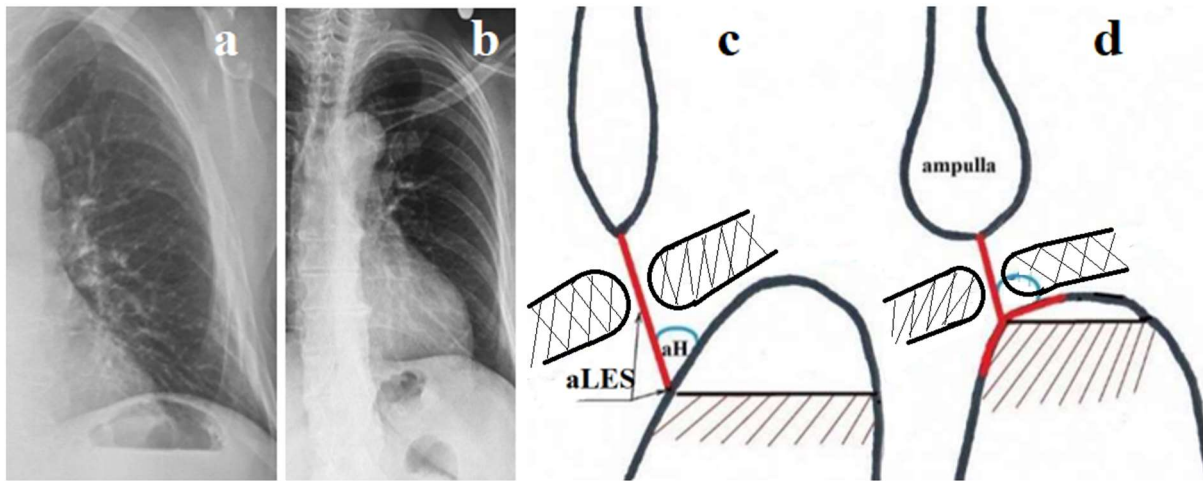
(a-b). Radiographs of the left dome of the diaphragm of a healthy person (a) and a patient with GERD (b). (c). Scheme of the EGJ with normal LES function (red). The angle of His (aH) is acute. Large gas bubble in the stomach. (d). In GERD, the LES is shortened because the abdominal part of the LES (aLES) is not functioning. This leads to an increase in the angle of His and a decrease in the gas bubble of the stomach, because of belching.
